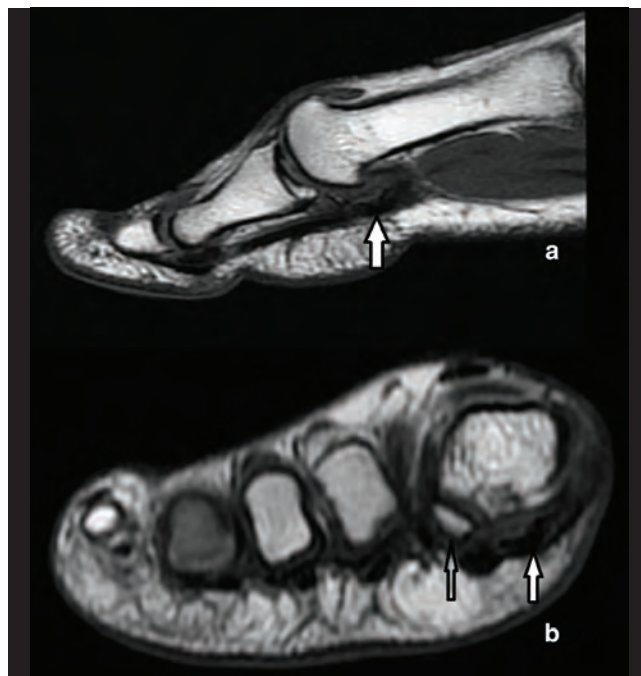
Decreased dimension and signal consistent with osteonecrosis are observed in the medial sesamoid bone (white arrow) in T1-weighted magnetic resonance imaging performed in sagittal (a) and coronal (b) planes. Lateral sesamoid bone (b) is of normal size and normal signal intensity (hollow arrow).
